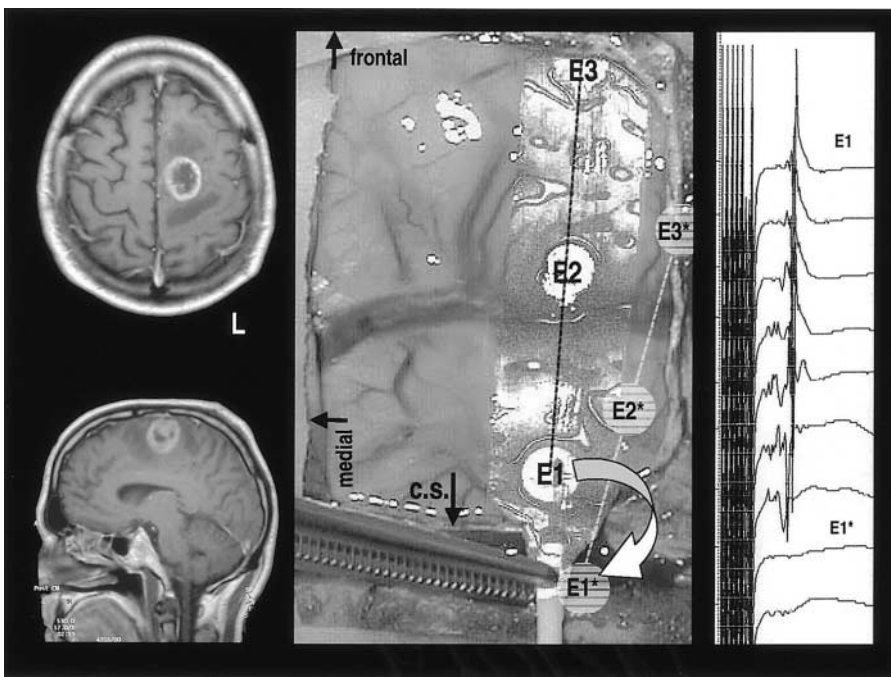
Case 2 – Axial and sagittal MR images showing a left frontal lung cancer metastasis in a 57-year-old male. CMAPs were recorded from the right thenar muscle after stimulating electrode *E1*. Electrode shift occurring during tumor resection is demonstrated on the intraoperative image. Immediate loss of potentials was due to displacement of electrode *E1* towards its new position *E1\. *L* Left; *c.s.* central sulcus
